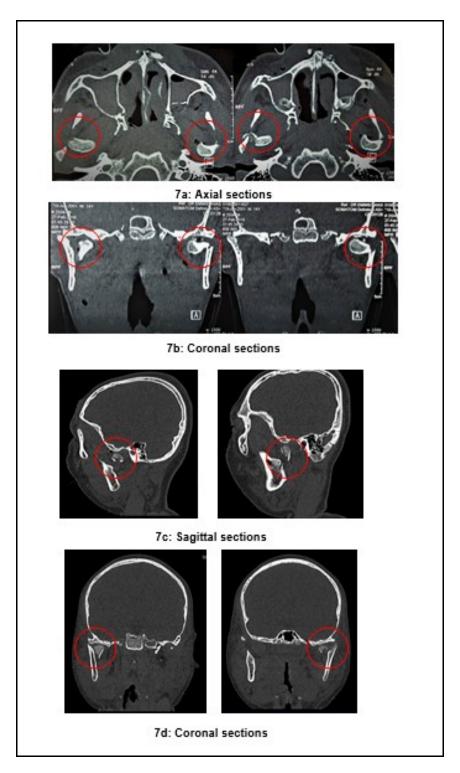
2-D CT showing bilateral mandibular condyle fractures in different views
